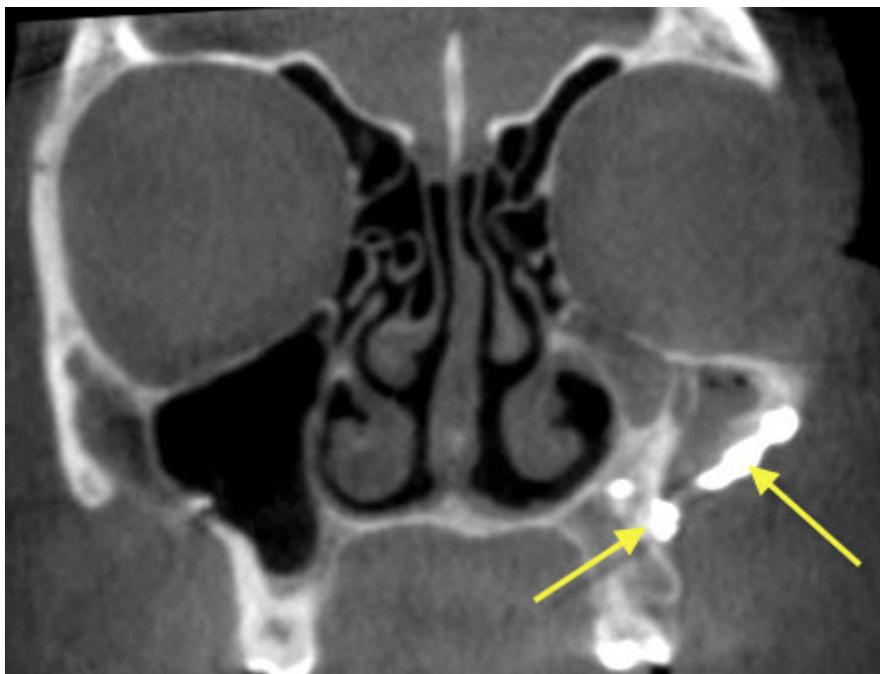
CBCT coronal section showing chronic sinusitis and thickening of the walls (arrows) of the right maxillary sinus
